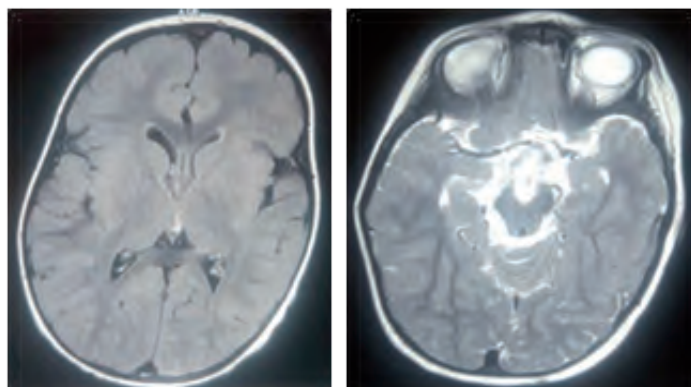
Axial, sagittal and coronal MRI scan after 4 months of surgery. The size of the cyst decreased and hydrocephaly improved after the procedure.
